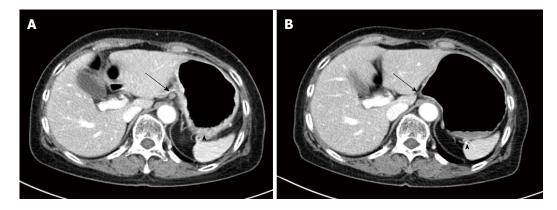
Response evaluation after 2 cycles of docetaxel chemotherapy (A, B). Abdominal CT scan shows decreased perigastric lymph modes (arrows) and gastric mucosal thickening (arrowheads).
